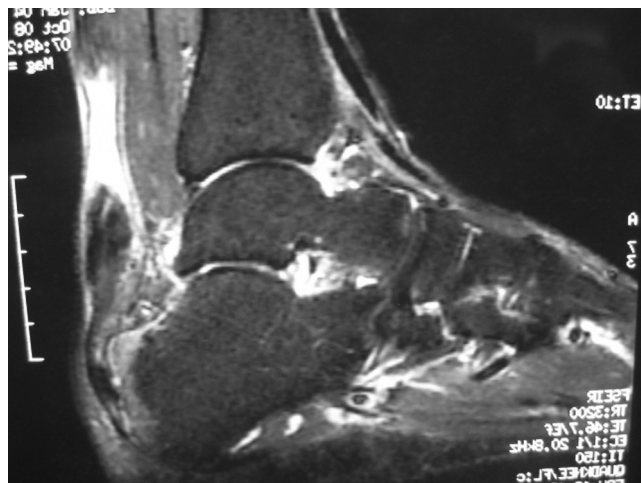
Magnetic resonance imaging scan showing an Achilles tendon rupture with retraction and gapping between the tendon ends.
